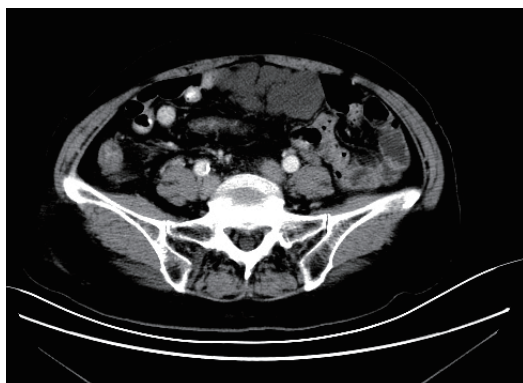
Abdominal computed tomography scan reveals lumpy low-density shadows around the upper middle intestine, 86 mm × 42 mm in size, and no enhancement was observed (Case 4).
